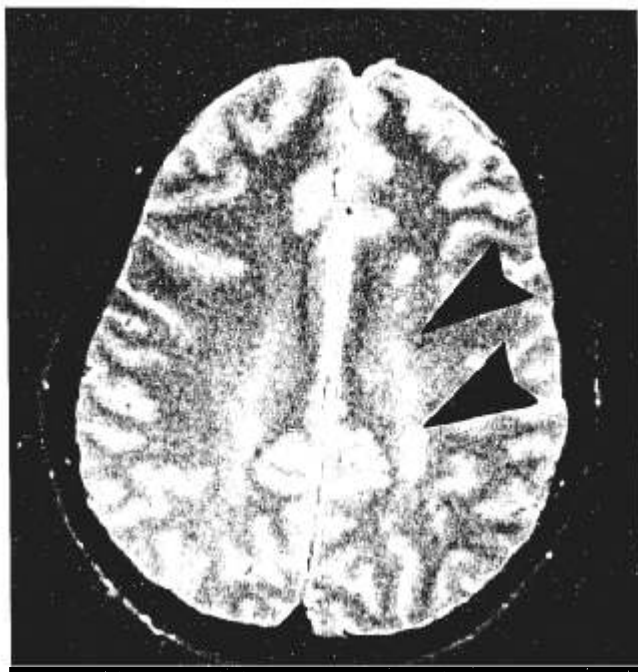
Patient 1. Magnetic resonance image (MRI) scan showing many small lesions within the periventricular areas and in the left corpus callosum region. This patient had prolonged saccade reaction times particularly for right-going saccades.
